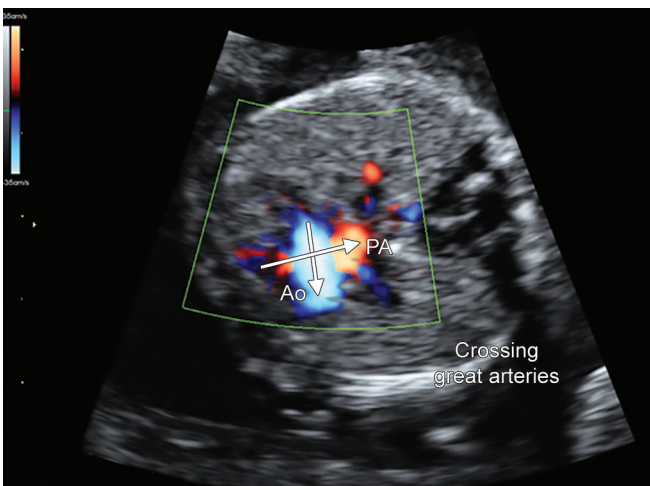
Early fetal echocardiography by 2D and BiFlow in a structurally normal heart. BiFlow is particularly useful to demonstrate the crossing of the great arteries (Abbreviations: Ao: Aorta; PA: Pulmonary artery)
